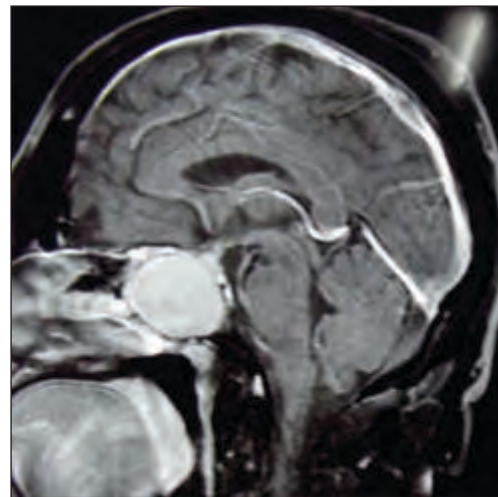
MRI sagittal cut T2 weighted image showing mucocele in sphenoid displacing the pituitary fossa posteriorly
